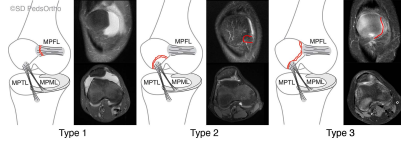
Classification of medial patellar injuries in the setting of patellar instability based on fracture characteristics and ligamentous insertion site. Rendering and MRI examples demonstrated above. Left images demonstrate a Type 1 injury (no fracture – purely ligamentous). Middle images demonstrate a Type 2 injury (fracture fragment below the equator of the patella – MPFL). Right images demonstrate a Type 3 injury (complete fracture spanning above and below the equator of the patella – MPFL and MPFL).
